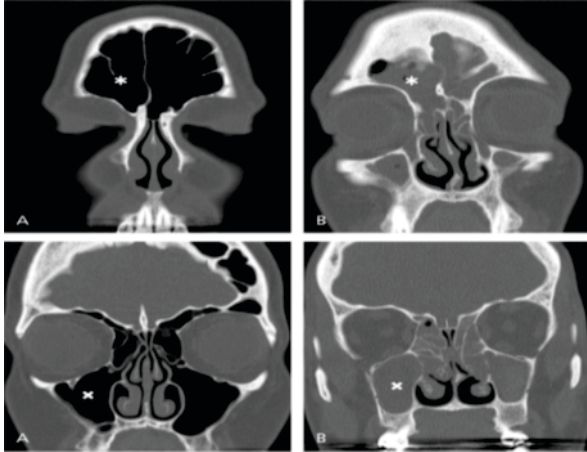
Coronal cuts from sinus computed tomography scans. (A) Normal scans showing well-aerated (black area) sinuses. (B) Scan showing opacification (gray area) of the paranasal sinuses, which is consistent with chronic rhinosinusitis. The frontal sinuses (asterisk) and maxillary sinuses (x) are marked for orientation.
